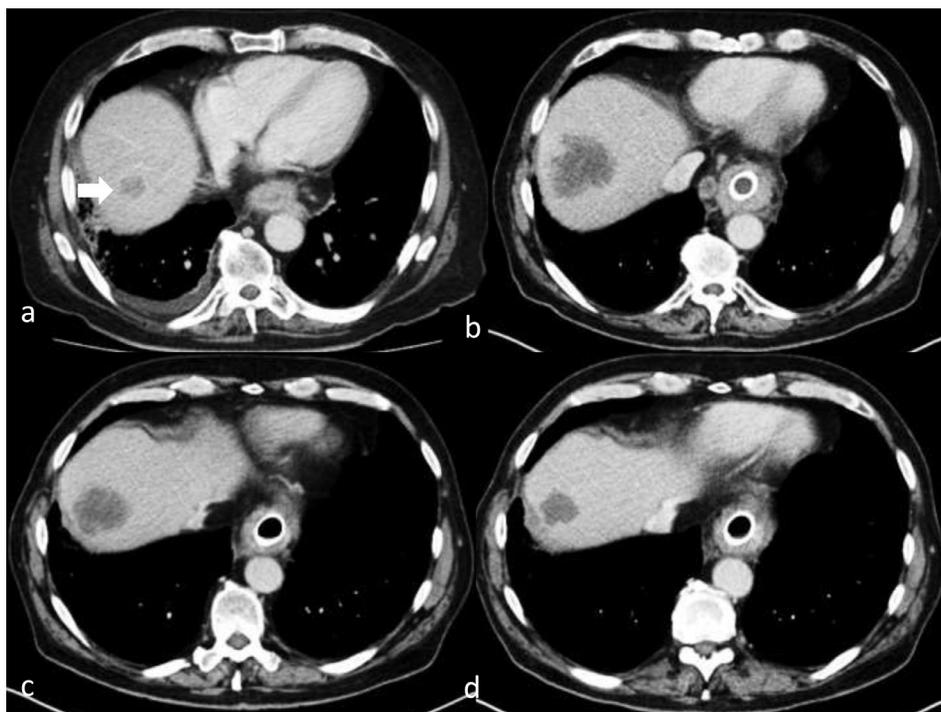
Case 3: Contrast-enhanced CT images acquired at baseline (a), at 8 weeks (b), at 4-week follow-up after disease progression (c) and at 6 months (d). At 8-weeks follow-up the hepatic metastasis in segment VIII (arrow) had increased in size (+55%) and new lesions had appeared within the liver in keeping with disease progression. The 4-week CT follow-up showed favorable response of the liver metastases suggesting pseudoprogression." At 6-months ongoing response was again observed.
